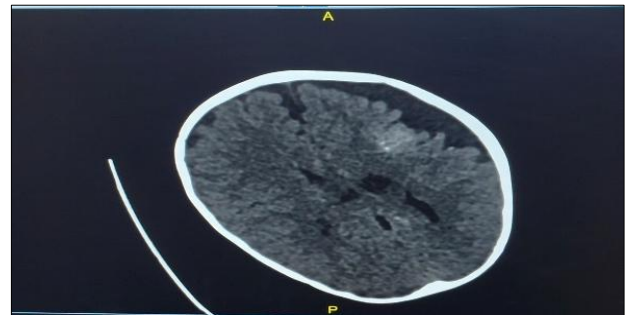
CT brain showing left cerebral atrophy.
